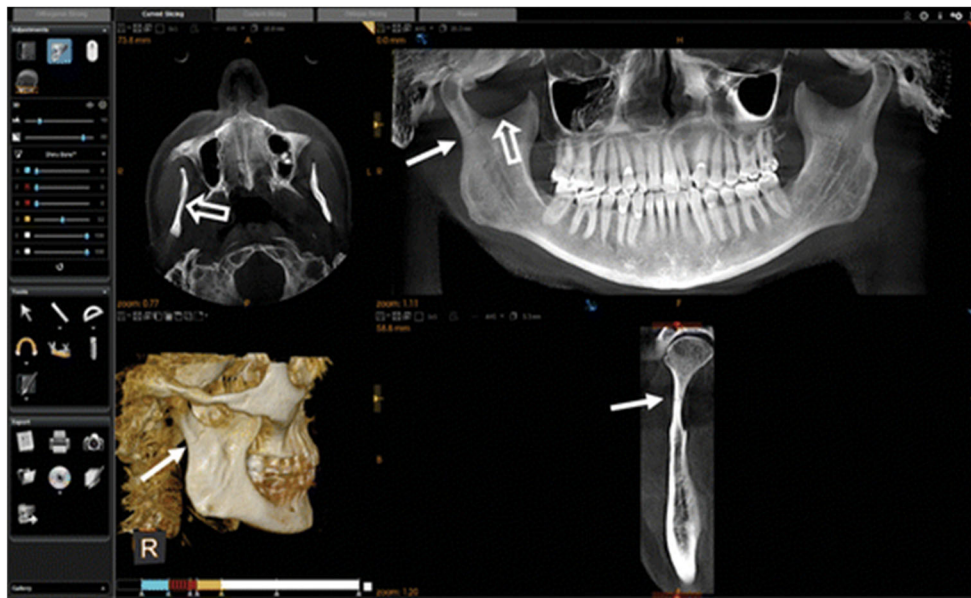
Images obtained in a 60-year-old woman with jaw pain after a fall from standing. Cone-beam CT was performed by using a medium field-of-view scanner (Carestream 9300 3D; Carestream Dental, Atlanta, GA). A screen capture of images obtained by using three-dimensional software highlights the volume visualization capabilities and ultra-high resolution of cone-beam CT. Axial thick cone-beam CT image with multiplanar reformation (*top left*), curved planar cone-beam CT image with reformation of the mandible (*top right*), three-dimensional volume-rendered image (*bottom left*), and coronal oblique cone-beam CT image
